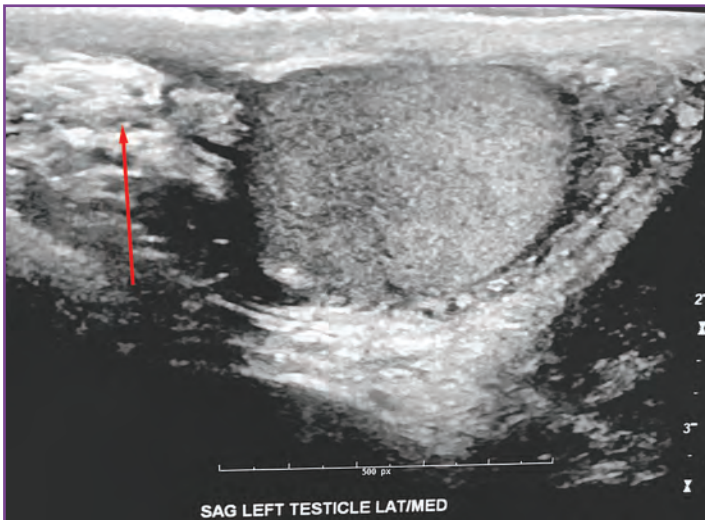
Ultrasonographic image of inguinal hernia containing omentum and bowel (arrow).
